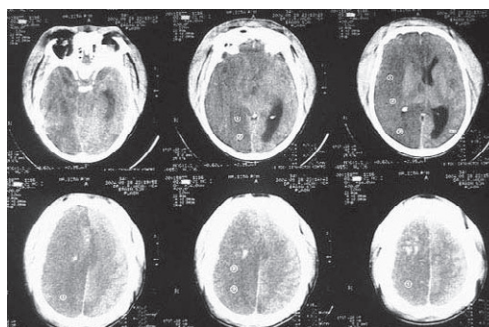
Axial CT shows hypo density involving the grey white matter of the right fronto parietal and temporo occipital region. There is interhemispheric subdural bleed, brain swelling ,midline shift and uncocal herniation with hypodensity on other side adjacent to falx
